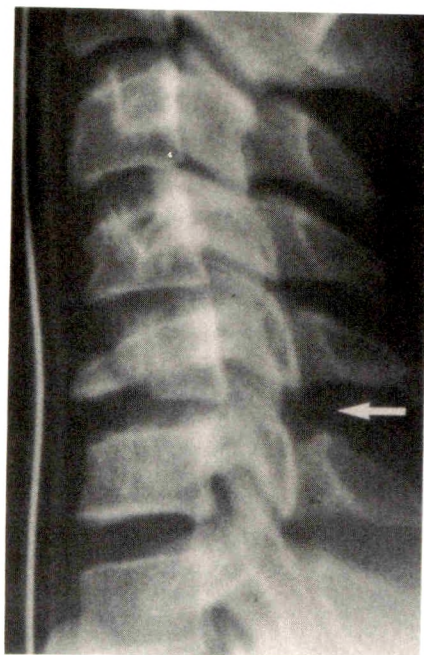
14-year-old with incomplete quadriplegia at C6 as a result of diving accident. Lateral radiograph, obtained after traction tongs are applied, shows flexion teardrop fracture at C5 with a mild degree of kyphotic angulation. Posterior fragment is slightly displaced backward in inferior aspect; disk space between posterior fragment and vertebral body below is narrowed; interlaminar and interspinous spaces are widened at C5–C6 (arrow); C5–C6 facet joint is widened; and fractured C5 body shows anterior wedging deformity. There is also compression deformity in anteroinferior aspect of C4 body.
